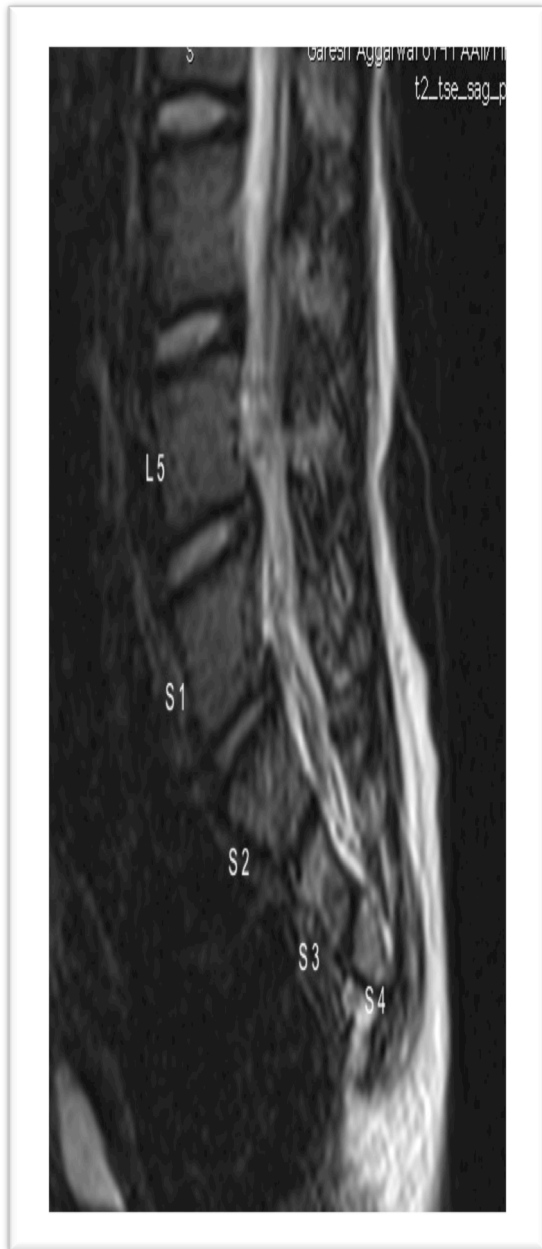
MRI (non contrast image) sagittal section showing absence of caudal segment of sacrum with entire coccyx vertebrae.
